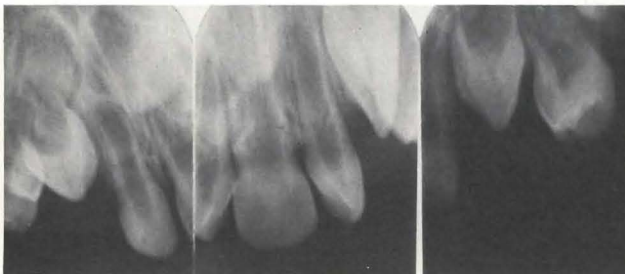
Apical radiographs showing the dental development in the maxillary incisor region. There appears to be only one tooth bud for the maxillary permanent central incisor.
